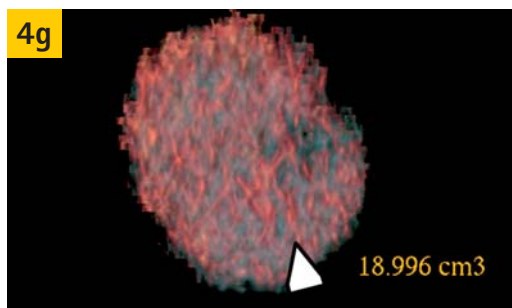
f and g: At contrast-enhanced CT, the lesion was as much enhanced as the normal cortex. However, the cranio-caudal length was underestimated and was over 4 cm. The true tumor volume was almost reaching 19 cm³.
